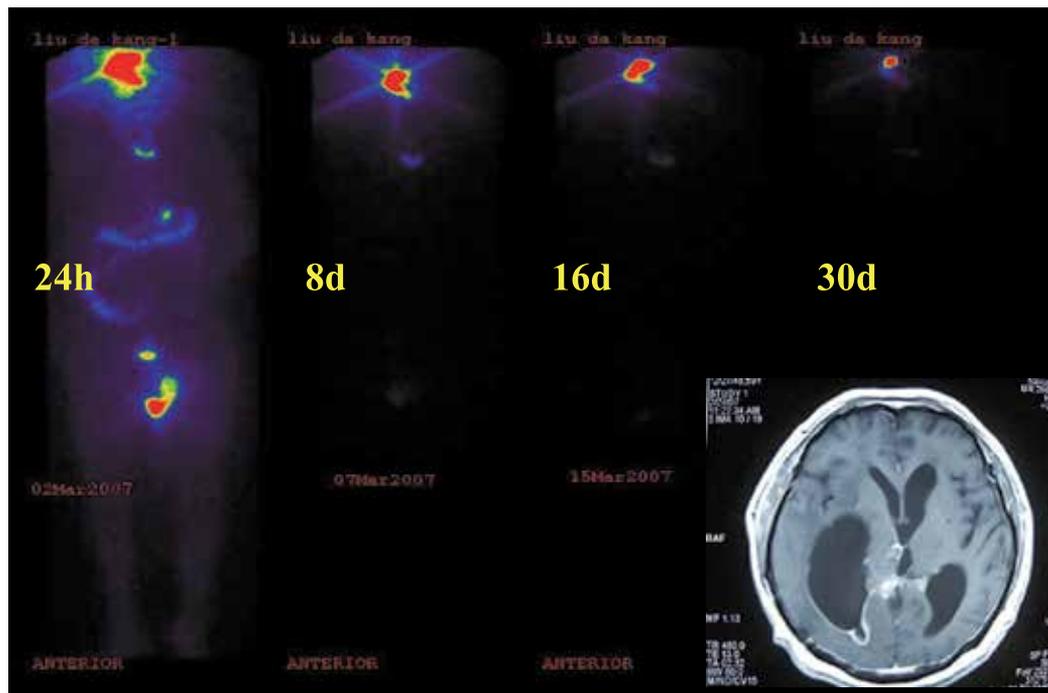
CT and ECT at 24h, 8d, 16d and 30d after intratumoral interstitial brachytherapy.
